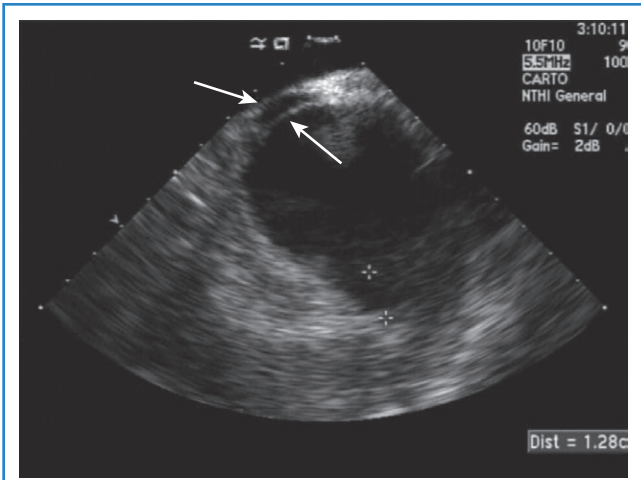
Intracardiac echocardiography (ICE) image obtained before trans-septal puncture showing a double septum. This highlights the importance of ICE while performing trans-septal access in cases with unusual anatomy.
